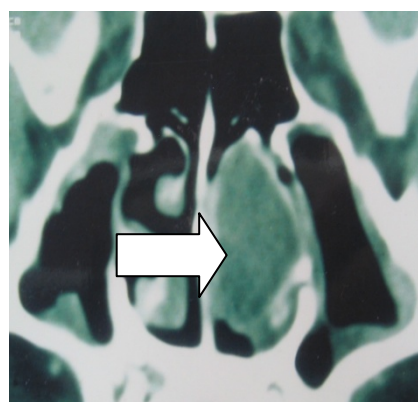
CT scan picture showing cystic mass (arrow) arising from the lateral wall of the left nasal cavity
